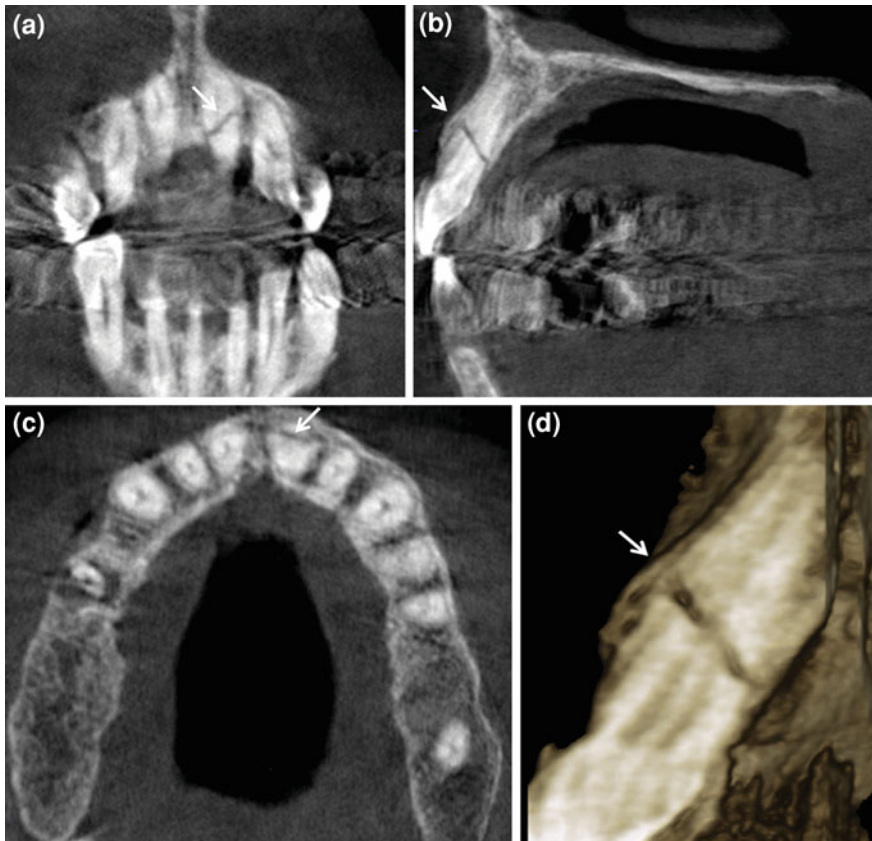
CBCT coronal (a), sagittal (b) and axial (c) scans showing a horizontal fracture (*thin arrow*) in middle third of root of left maxillary central incisor. Note the 3D model of left central incisor (d)
